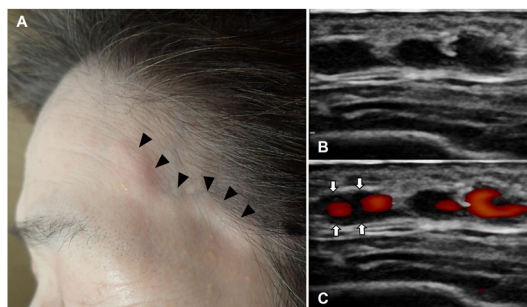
Nodular swelling of the temporal artery (arrowheads) (A) and ultrasound images showing the halo sign as a hypochoic area surrounding the artery (arrows) and stenosis as an area of no colour Doppler (B, C).
